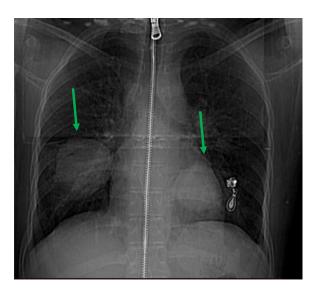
Frontal chest X-ray showing 2 well-defined water-density opacities located in the bilateral lower lobes (green arrow).
